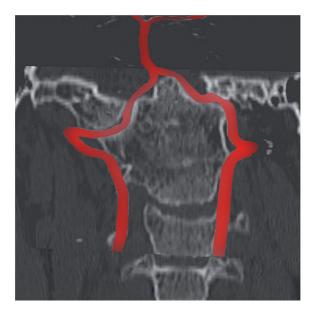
Reconstructive coronal CT image of the patient that iatrogenic vertebral artery injury occurred. This image was not created and seen before the surgery. VAs curve below the occipitalis atlas lateral mass at the C1-2 facet joint level then enter the cranium (This image was not originally a CT Angiography but reconstructive images of the patient was created after the surgery which VA injury occured to see the anomalous course of the VAs).
